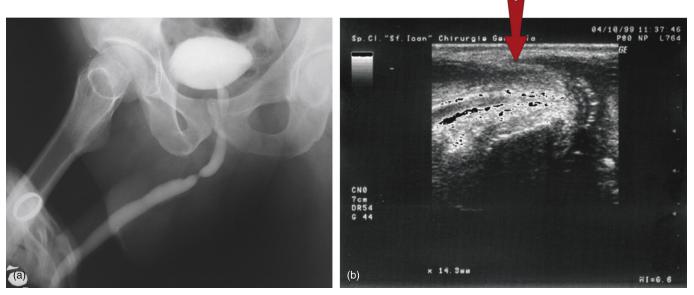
Stricture of the penile urethra (postbulbar) (a) with spongiofibrosis at 12 o'clock seen at ultrasound exam (b).
